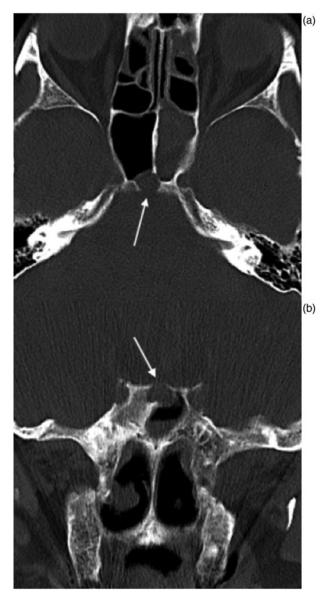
Case 1: showing (a) pre-operative axial and (b) coronal computed tomography scan images showing bone erosion of the posterior wall of the sphenoid sinus and clivus (white arrows); (c) pre-operative axial and (d) sagittal T2-weighted magnetic resonance imaging demonstrating a homogeneous and hyperintense cystic lesion in the posterior wall of the sphenoid sinus that derives from the prepontine cistern.
